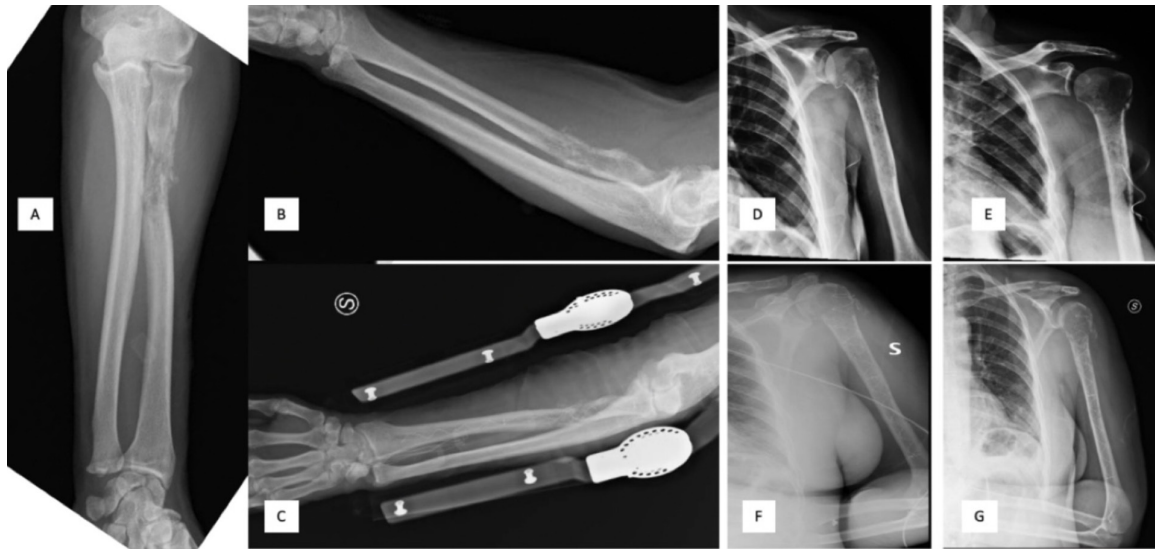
Pre (A-B) and post-surgery (C) x-ray of a patient with pathological fracture of the left radius (case 1 of this series). Pre (D-E) and post-surgery (F-G) x-ray of a patient with pathological fracture of the left proximal humerus (case 6 of this series).
